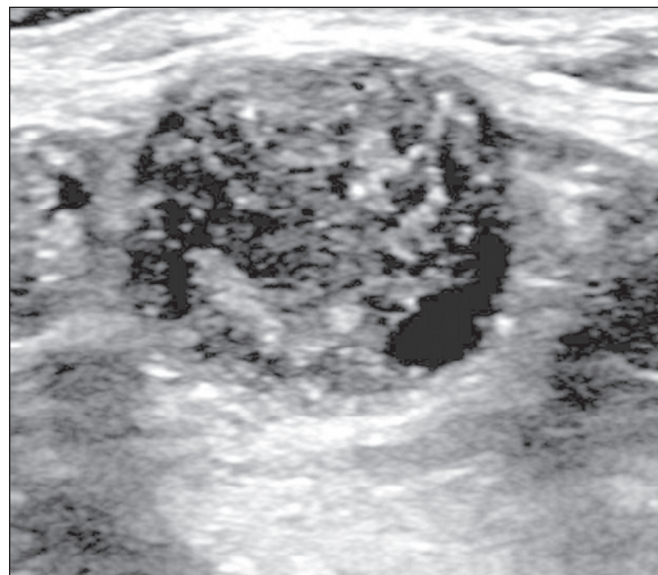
Ultrasound showing a rounded nodule with circumscribed, hypoechoic margins, containing some echogenic foci (calcifications), and posterior acoustic shadowing in the lower inner quadrant of the left breast. Analysis of a percutaneous biopsy of the mass revealed that it was secondary to an ovarian carcinoma.
